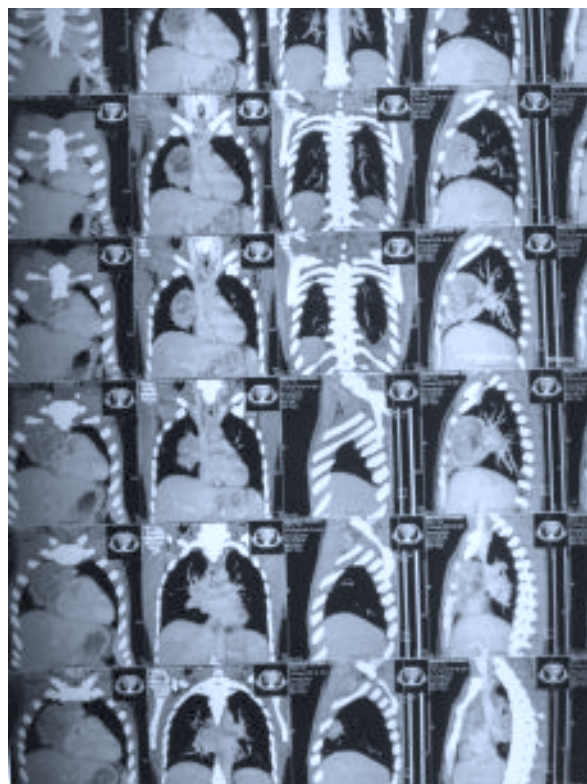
CT scan of chest coronal and saggital view showing mediastinal mass .
